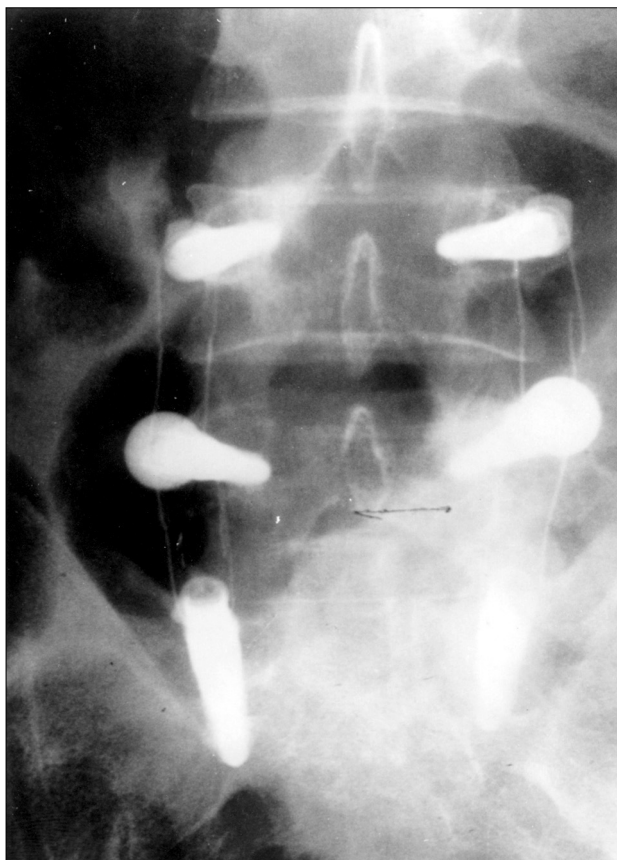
Radiographs taken after insatallation of Graf fixation system. Plain Lumbar AP(left) and Lateral(right) films show screws and tension bands.
